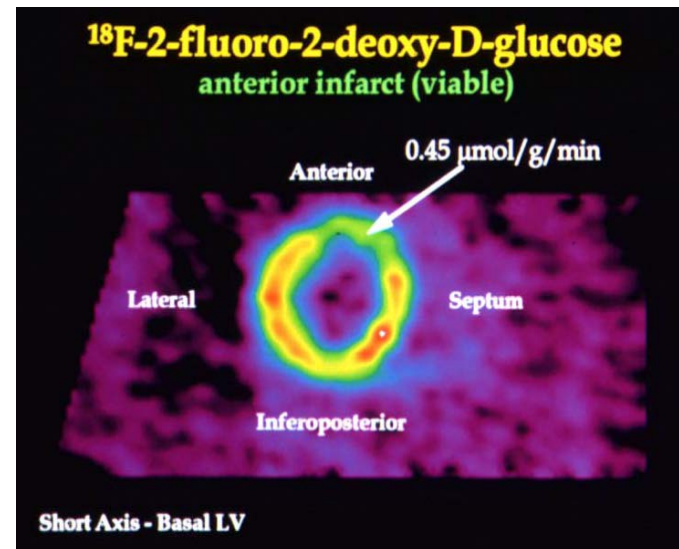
Image quality with FDG-PET depends on co-morbidities such as diabetes: importance of acquisition protocol
